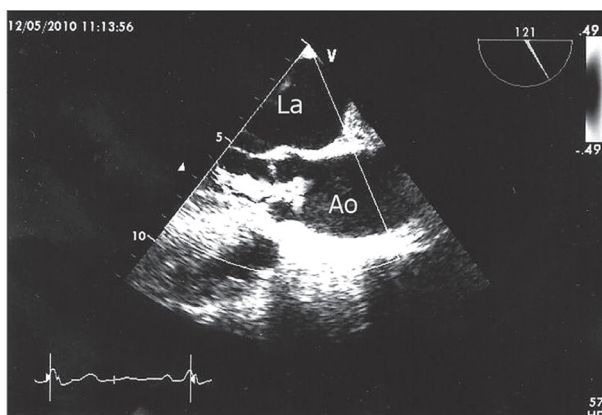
Transesophageal echocardiogram (long axis view) of the quadricuspid aortic valve and ascending aorta (Ao) during diastole, with incomplete cusp closure and moderate AR. La = left atrium; Ao = aorta
